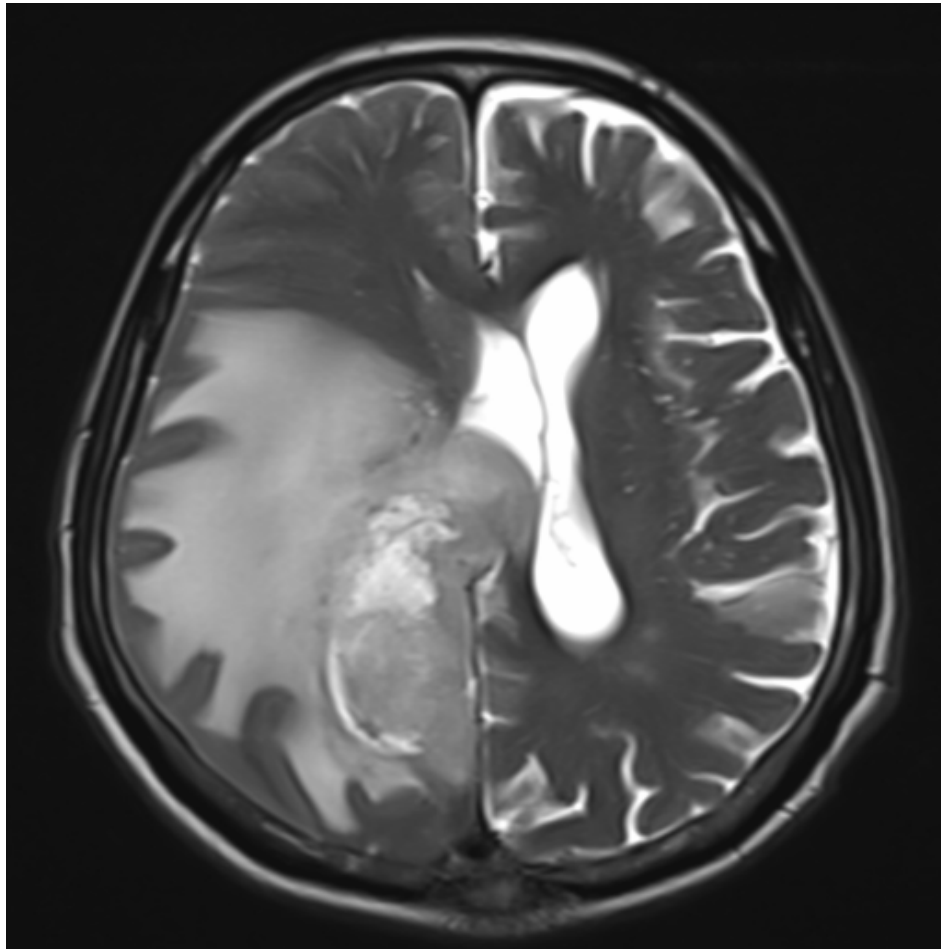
MRI brain – S966/18, Pareito occipital glioblastoma (IDH1 & EGFR negative) – ring enhancement present
